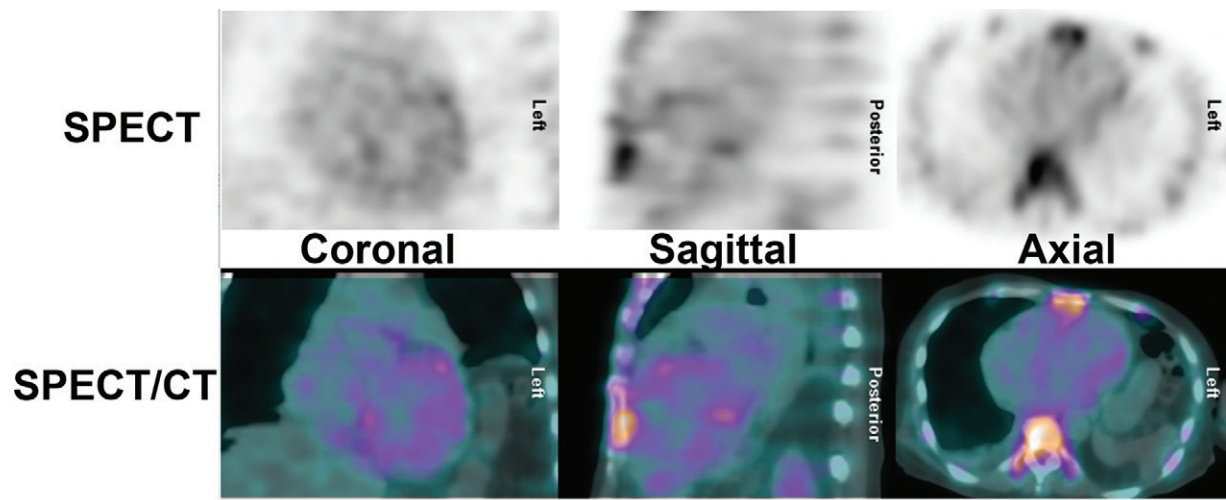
False-negative technetium 99m (^{99m}Tc) pyrophosphate (PYP) scan in hereditary transthyretin (ATTRv) amyloidosis. An 82-year-old African American man presented with symptoms of heart failure. Investigations revealed typical echocardiographic features of an infiltrative pathologic abnormality, and he was found to carry the Val122Ile (p.Val142Ile) transthyretin (ATTR) gene variant. His ^{99m}Tc -PYP SPECT/CT scan was, however, surprisingly, negative. The diagnosis of ATTRv cardiomyopathy was confirmed approximately 6 months later postmortem when the autopsy revealed extensive ATTR amyloid fibril deposition in the myocardium. Rarely, in patients with the Val122Ile (p.Val142Ile) variant, ^{99m}Tc -PYP scans can be negative. False-negative scans are more commonly encountered in patients with ATTRv with certain pathogenic ATTR variants, such as Phe64Leu (p.Phe84Leu) and Val30Met (p.Val50Met).
